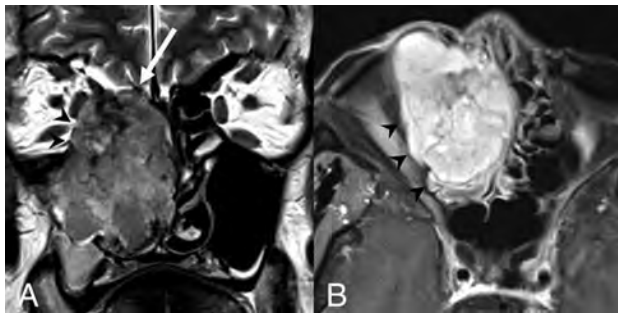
Biphenotypic sinonasal sarcoma. Coronal T2 (A) and axial T1 postcontrast, fat-saturated (B) MR images show a well-margined but locally aggressive right nasoethmoid mass involving the right maxillary sinus. The mass extends through the right lamina papyracea to involve the right orbit (black arrowheads) and through the right lateral lamella and fovea ethmoidalis into the right anterior cranial fossa (white arrow). Heterogeneous but predominantly isointense signal relative to the cortex and avid contrast enhancement are noted.
